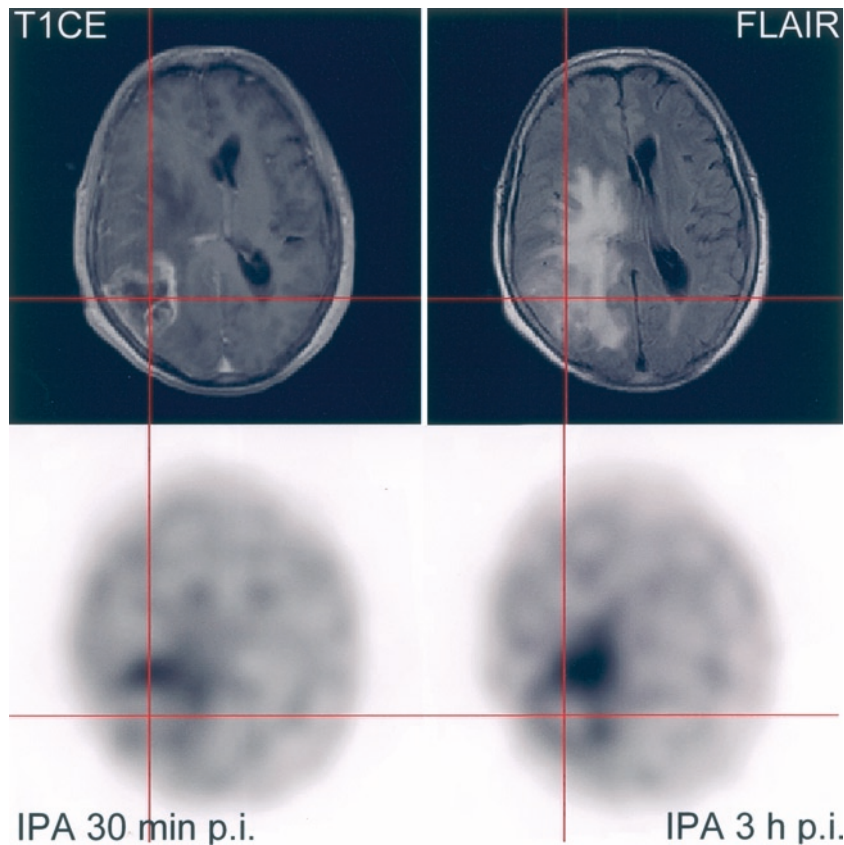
MRI scans (T1CE and FLAIR) as well as early and delayed IPA-SPECT in a 63 year old female with initial diagnosis of glioblastoma. Note the increasing uptake in the central tumour areas with hyperintensity in FLAIR images without contrast enhancement in T1CE indicating an intact blood-brain-barrier in that area
